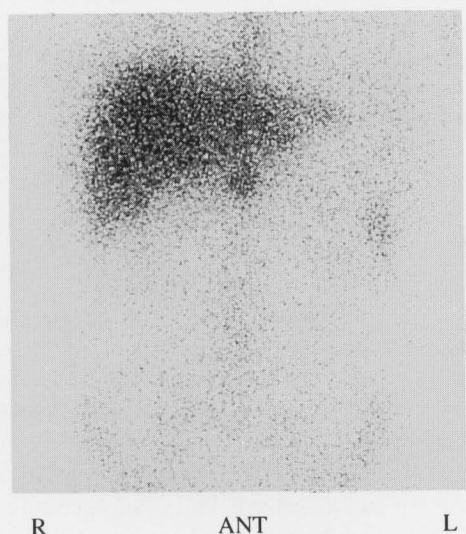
Ga-67 scintigraphy revealed an accumulation of radioactivity in the upper abdomen, but the diffuse accumulation in the abdomen decreased.
